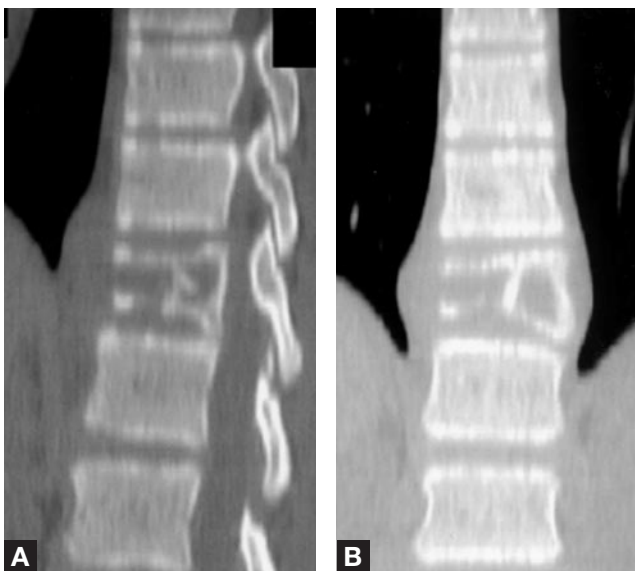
Sagittal and coronal computed tomography images reveal a lytic permeative lesion involving T12 vertebra with mild paraspinal soft-tissue changes.
